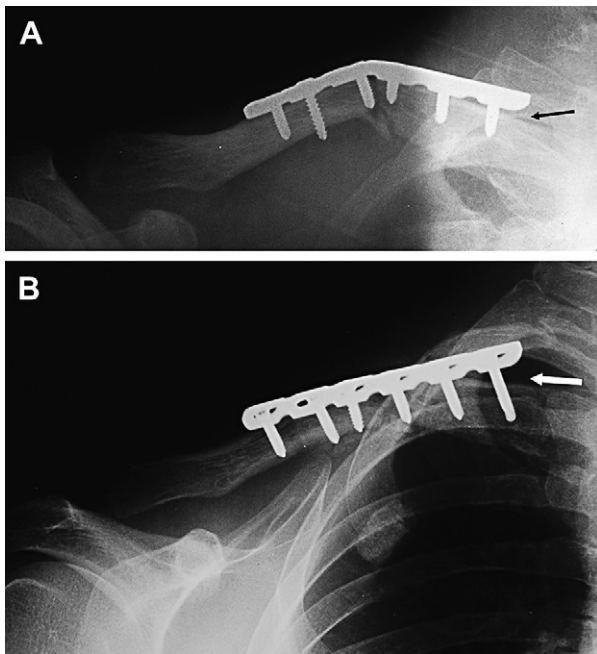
(A) Radiograph shows failure of the first fixation surgery by bending of the plate and pullout of the medial two screws (*arrow*). (B) Radiograph shows failure of the second fixation surgery by pullout of the medial screws (*arrow*).
